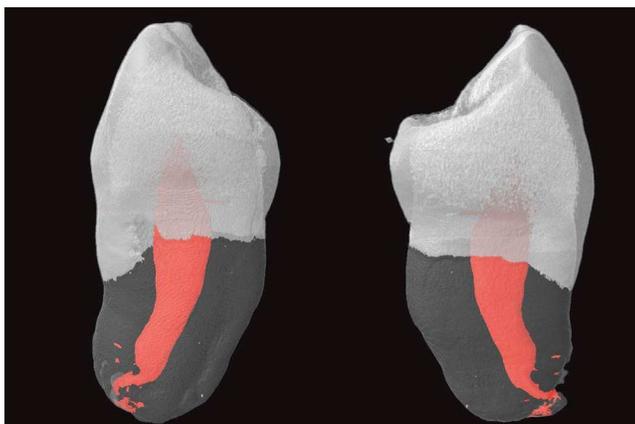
Three-dimensional computed microtomography of proximal surfaces (distal and mesial) of lower premolar with short root anomaly. In red, the dental pulp, and in white, the enamel (microtomographic X-ray Sky Scan 1076, NRecon and CTan software).
